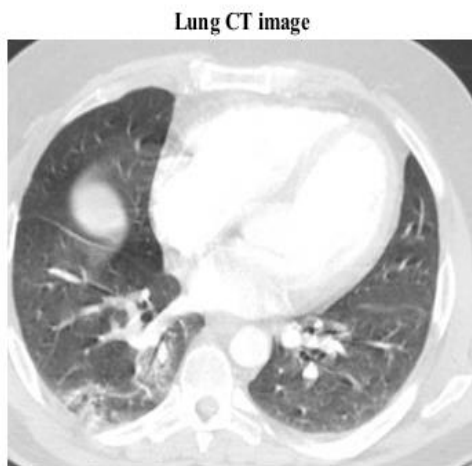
Input CT scan image
